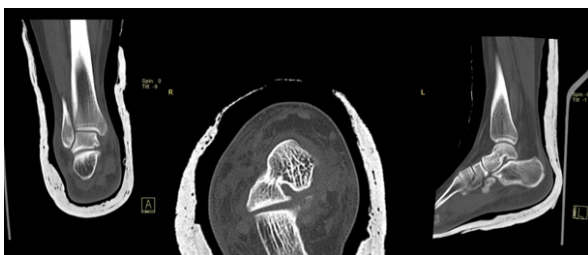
Plain CT scan of Right foot and ankle after reduction.
